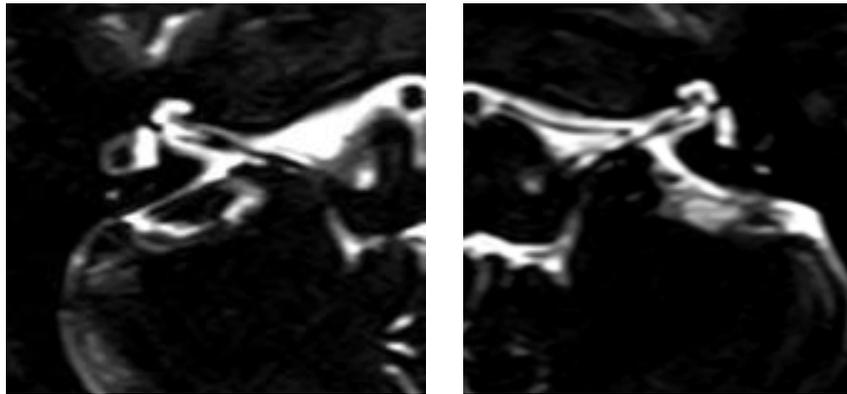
b. 3DT2 MR images in the same patient demonstrating the bilateral cochlear nerves entering the cochlear canal, right side(a) and left side (b).
